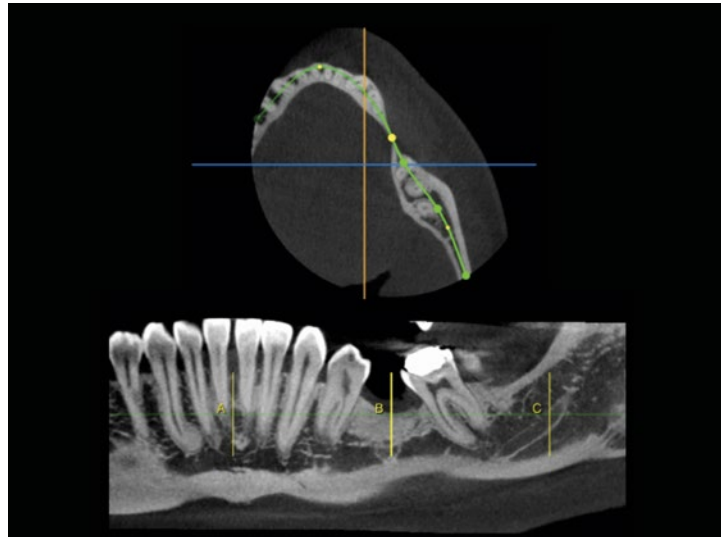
Top image – small volume CBCT axial slice. Bottom view – curved MPR view of the arch (plotted by the green line on the axial slice)
